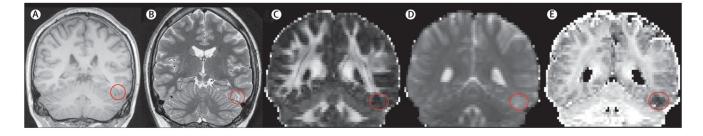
MRI acquisition protocols for the identification of structural cerebral abnormalities in epilepsy
